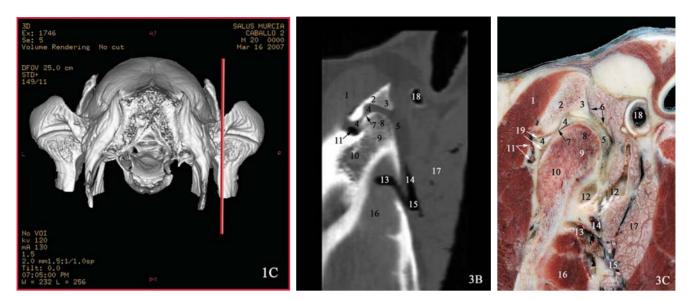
(A) Volume rendered 3D-reformatted image of the caudal view of the right TMJ showing a sagittal-sectional plane of reference for Figures 3B and 3C; (B) Bone window sagittal CT image (window width = 2354; window level= 154) and (C) sagittal anatomical section (lateral aspect) of the right TMJ. The progression of the CT and anatomical images was from lateral to medial aspect. The lateral aspect is on the top and dorsal aspect to the left side of the image. 1 = temporal muscle; 2 = zygomatic process of the temporal bone; 3 = retroarticular process; 4 = articular disc; 5 = caudal fibrous expansion of the articular disc; 6 = articular capsule (caudal ligament); 7 = articular cartilage; 8 = subchondral bone; 9 = mandibular condyle; 10 = ramus of the mandible; 11 = caudal deep temporal vessels; 12 = guttural pouch (wall); 13 = buccal vein; 14 = superficial temporal vein; 15 = maxillary vein; 16 = masseter muscle; 17 = parotid salivary gland; 18 = external auditory meatus; 19 = rostral compartment of the dorsal and ventral synovial pouches.
